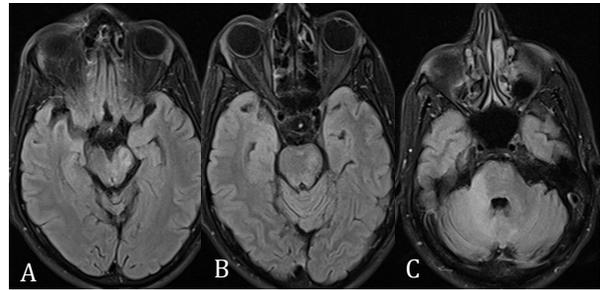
(A, B & C): MRI brain axial sections demonstrate similar T2 hyperintense lesions in left cerebral peduncle, mid-brain, left middle cerebellar peduncle and cerebellar hemisphere.
